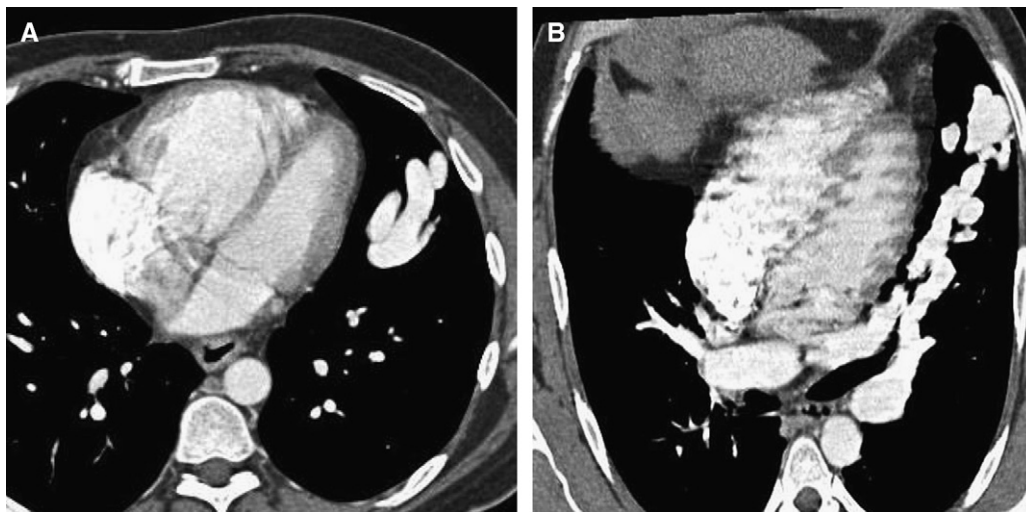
A 43-year-old man with hereditary hemorrhagic telangiectasia who presented after a transient ischemic attack. (A) Transaxial contrast-enhanced CT image, showing a large left-sided PAVM. (B) Maximum intensity projection reformat, showing an enhancing tortuous lesion, which connects with the left hilar vessels.
